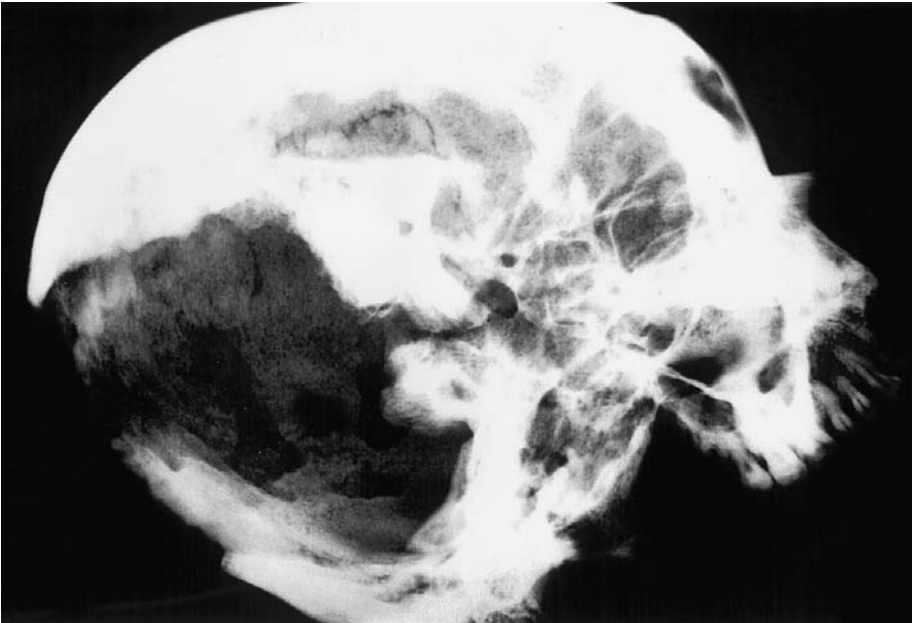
X-ray: Bony reaction on the cavity.
